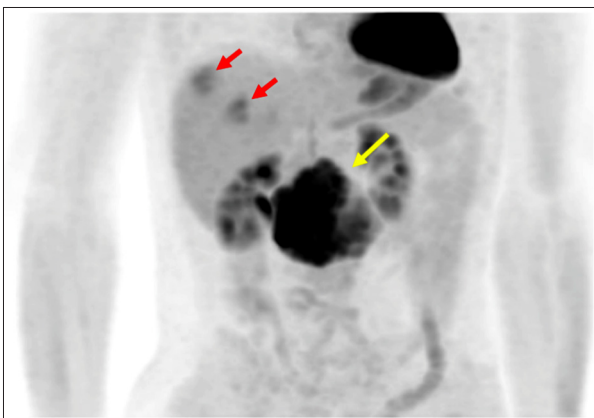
Positron emission tomographic image shows marked uptake in the inferior vena cava (yellow arrow) and 2 focal areas with relatively low standardized uptake value (SUV) in the liver suggestive of metastases (red arrows).
